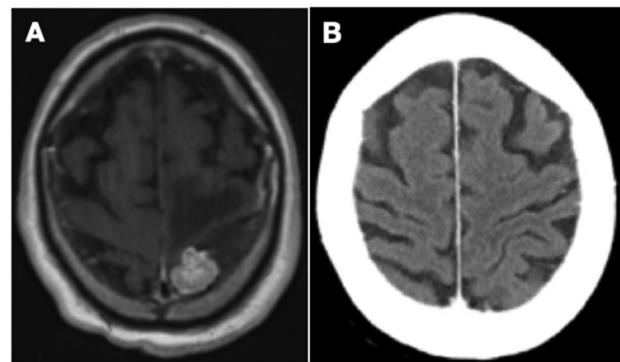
(A) Axial T1-weighted MRI of the head with contrast showing an enhancing mass in the superior medial aspect of the left postcentral gyrus. (B) Axial CT of the head with contrast showing no evidence of intracranial metastases following completion of whole brain radiotherapy and 6 cycles of chemotherapy.
